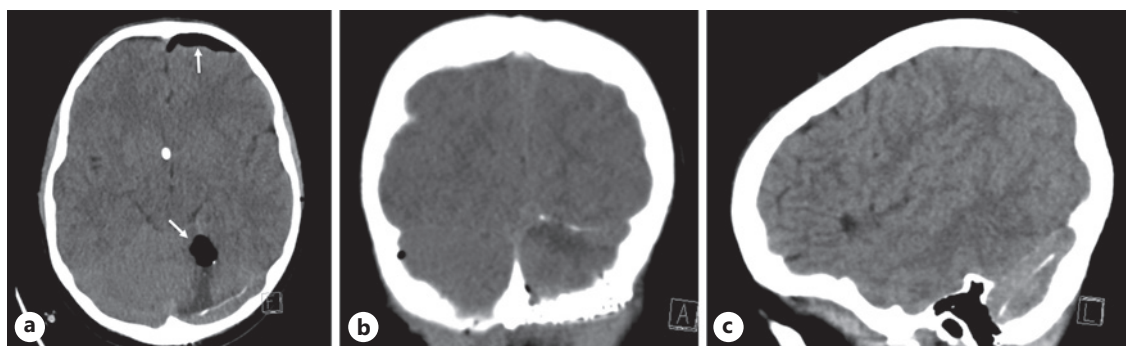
Post-surgery computed tomography scan demonstrating a thin linear object extending posteriorly from the resection cavity, reflecting the migrated Onyx. a Axial view (left). b Coronal view (center). c Sagittal view (right).
